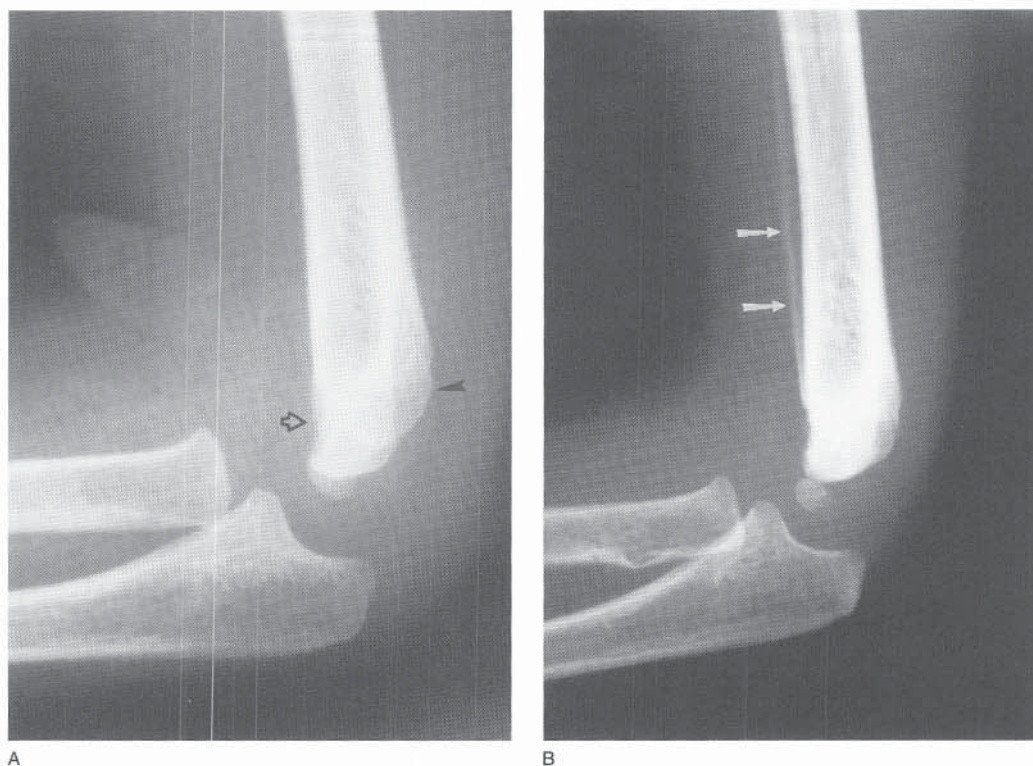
A, Lateral radiograph obtained after a hyperextension elbow injury in a child. Although there is no obvious fracture, there is a suggestion of a break in the anterior cortex (*open arrow*) as well as some buckling posteriorly (*black arrowhead*). B, Two weeks later, abundant periosteal reaction is evident (*arrows*).
